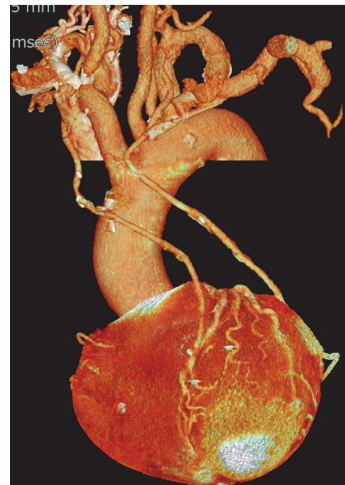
Postoperative CT angiography showing the patent bilateral ITA grafts.
